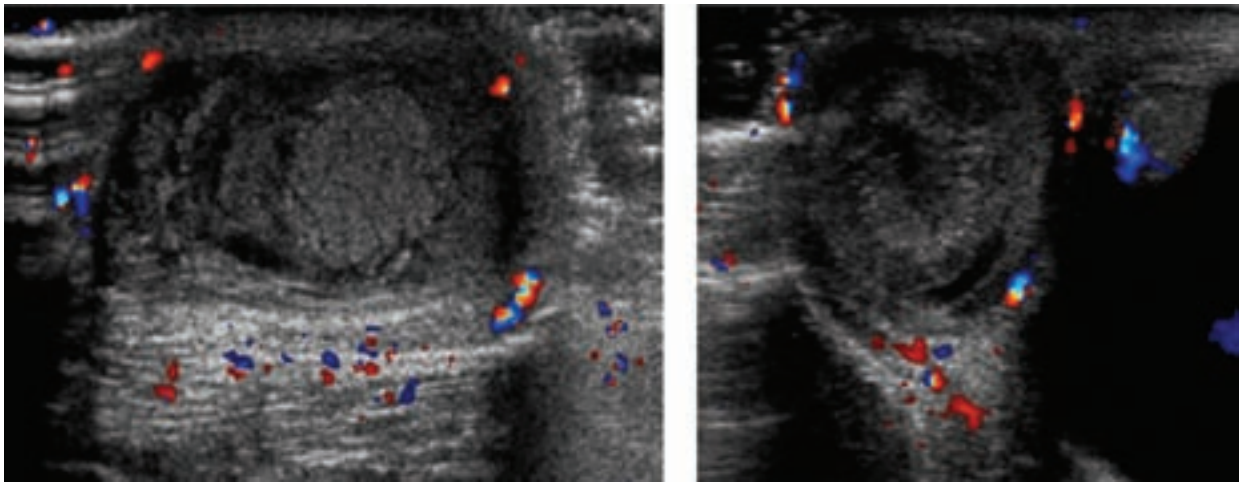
Sagittal (right) and transverse (left) view of the right testes demonstrating absent of arterial and venous flow on a color doppler ultrasound.
